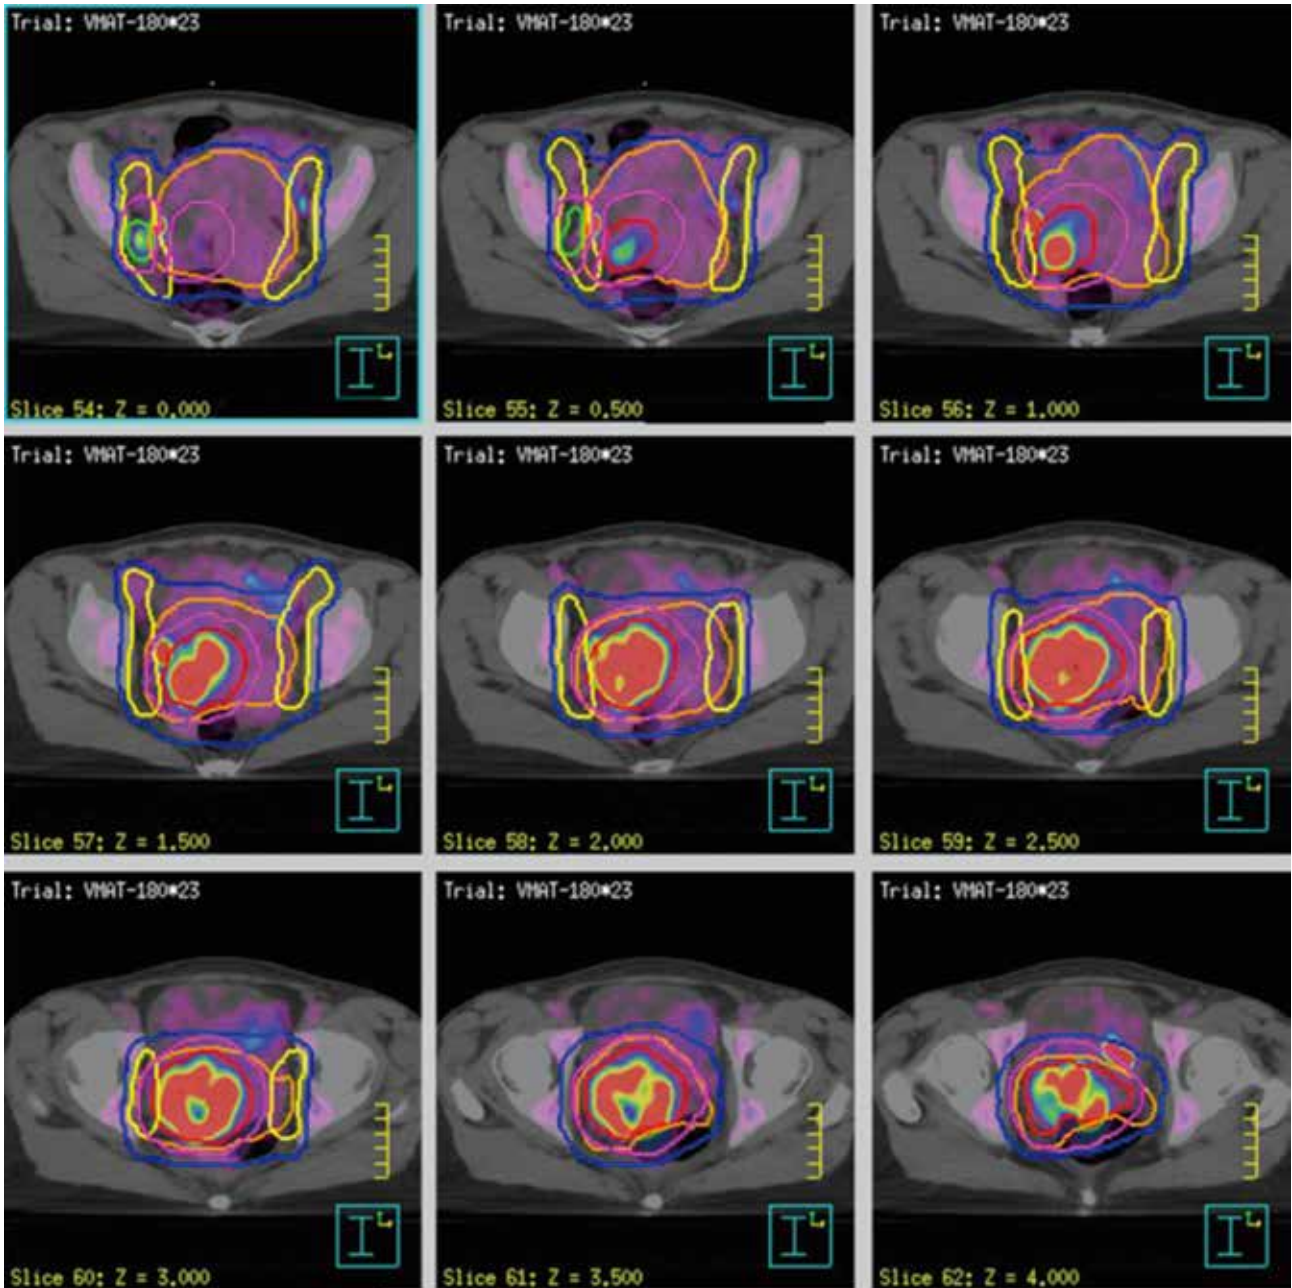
以 PET/CT 影像作為放射治療計畫中圈畫腫瘤照野劑量的參考
